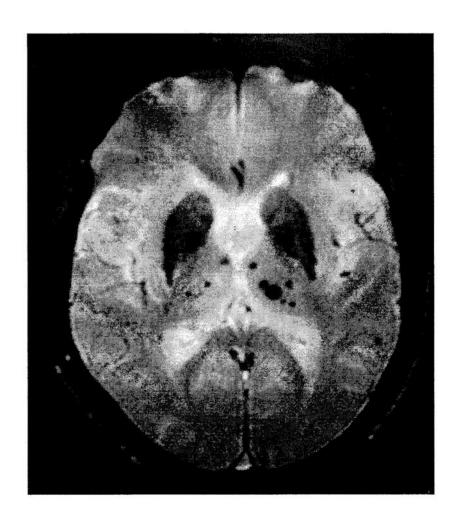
T2\* weighted gradient echo MRI of a 78-year-old woman with poststroke emotional lability shows multiple microbleeds in the bilateral thalami (mostly on the left), ranging from 2 to 8 mm in diameter.
